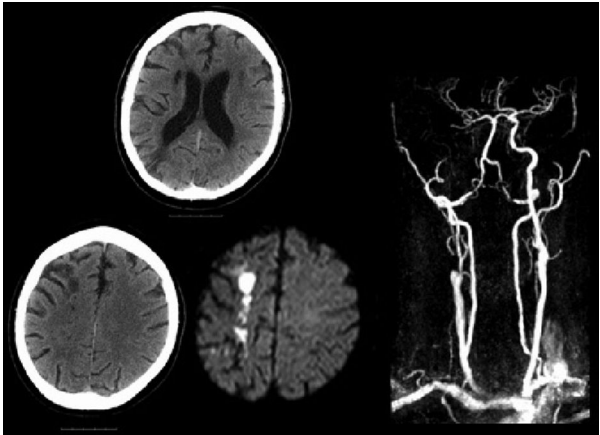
The figure shows imaging from a patient who has suffered an acute right hemisphere infarct. The MRI (diffusion) image clearly shows the new infarcts, which appear bright on the DWI image, in the right internal border zone region. The CT scans show low density in the anterior and posterior cortical watershed areas and low density in the corona radiata comparable to the MRI. The MRA show an occluded right internal carotid artery. © Hugh Markus.
